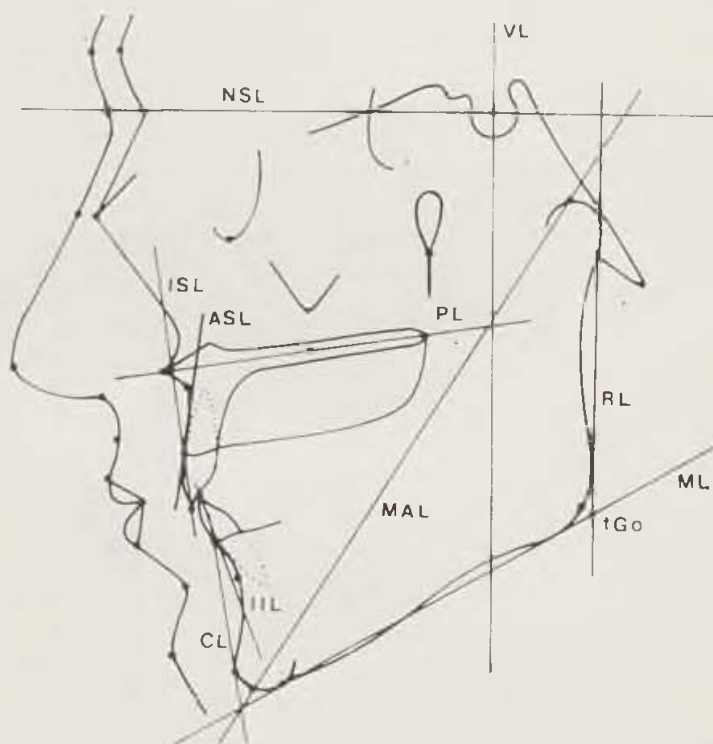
Reference lines plotted on lateral X-ray films: NSL — line through N and S, VI — perpendicular to NSL through S, PL — line through Sp and Pl, ML — tangent to the mandibular body through Gn, RL — tangent to the mandibular ramus through Ar, CL — line through Id and Pg, MAL — line through Cd and Pgn, ASL — tangent to the upper alveolar process through Pr, ISL — line through Is and Pr, IIL — line through Ii and Id
